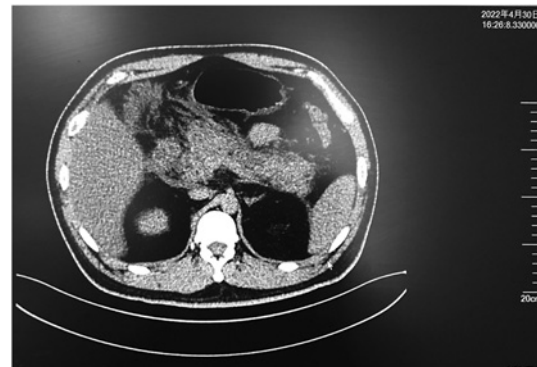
The first non-contrast-enhanced CT, the pancreas was enlarged with slightly reduced density and surrounded by free fluid.
